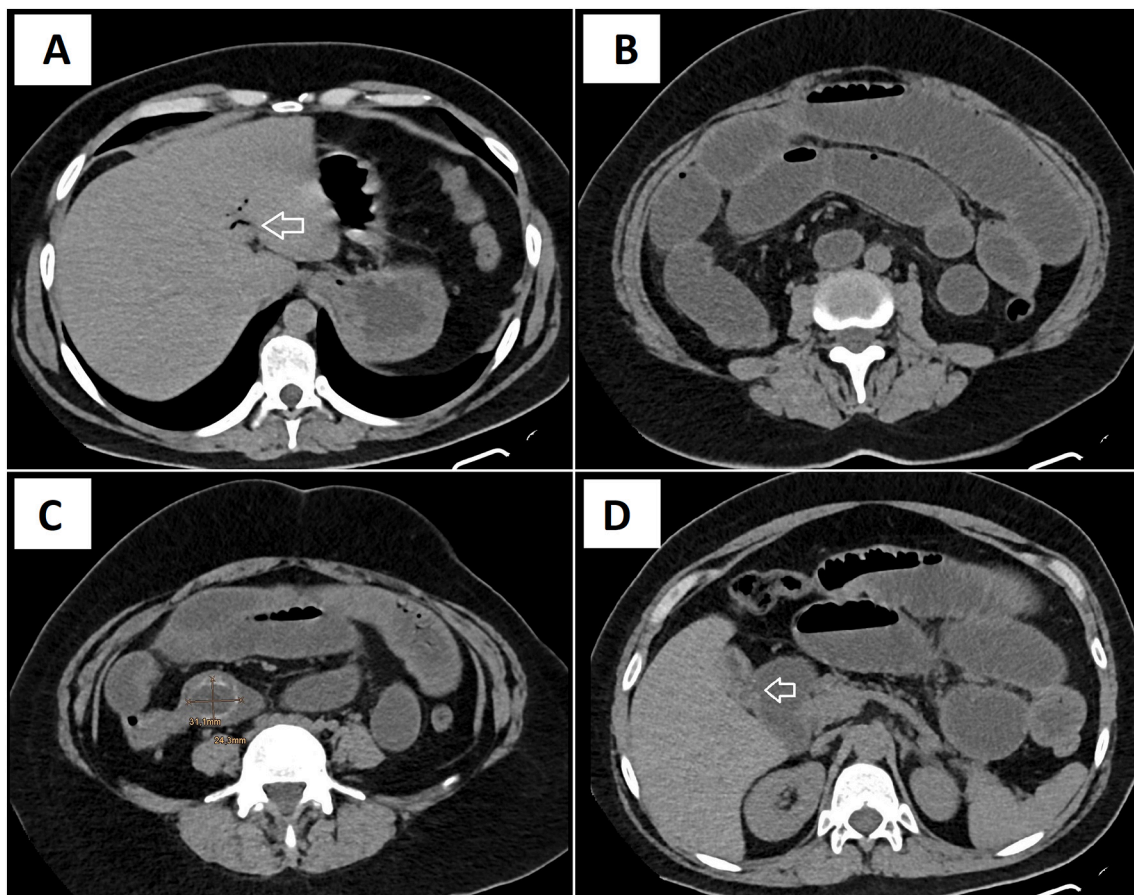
Abdominal CT scan showing the Rigler's Triad: aerobilia (A), dilation of intestinal loops (B) and ectopic gallstone measuring approximately 31.1 × 24.3 mm (C). There is also the presence of a fistula between the gallbladder with thickened walls and the gastric antrum (D).
